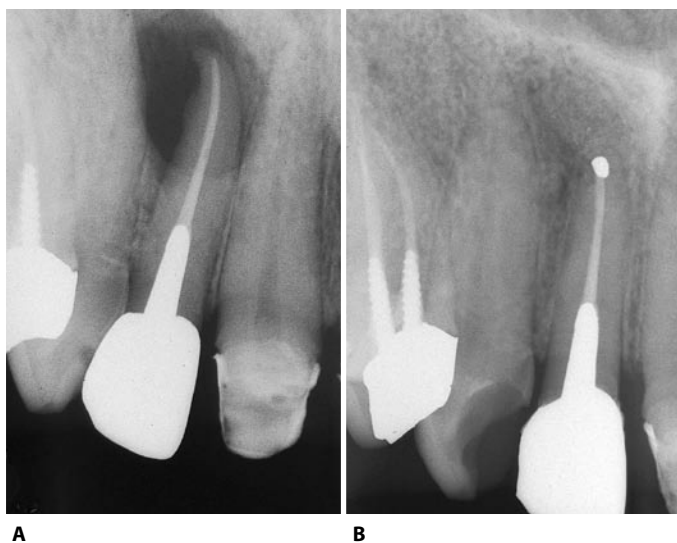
The use of straight instruments in the upper lateral incisors often leads to the formation of ledges or false canals, given the frequent distal or palatal curvature of the root. In these cases, surgery is often the only possible therapy. A. Preoperative radiograph. B. Three year recall after apicoectomy with amalgam retrofilling.
